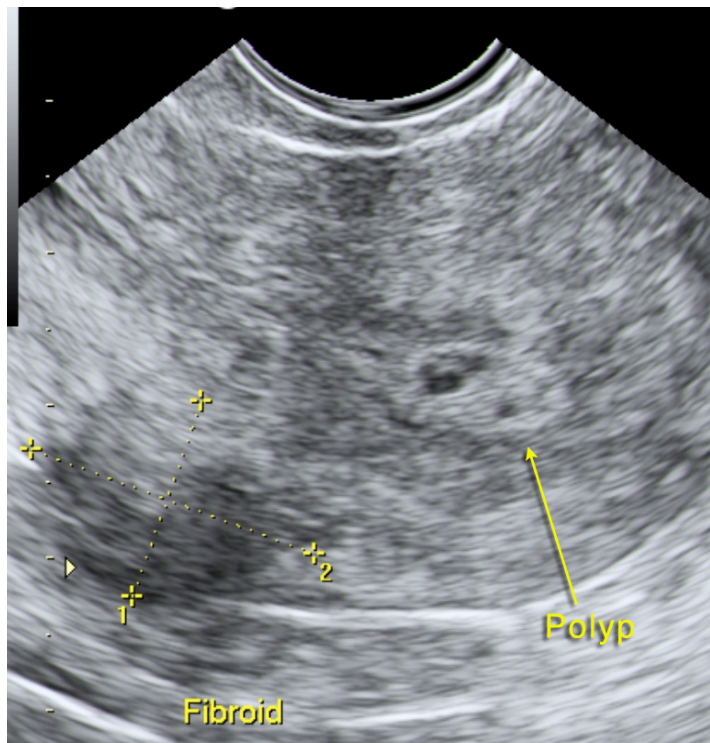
Transvaginal ultrasound showing a cystic endometrial polyp
